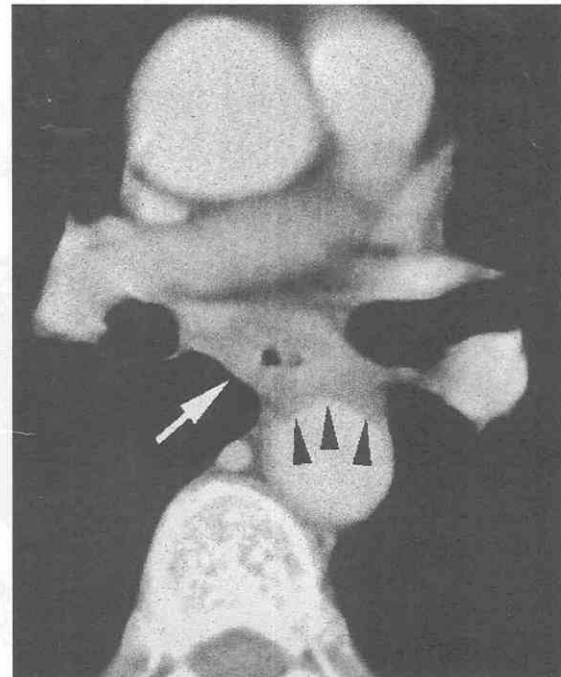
Esophageal cancer invading mediastinal fat. CT scan demonstrates circumferential wall thickening of the distal esophagus (arrow). The periesophageal fat is replaced by soft tissue attenuation (arrowheads).
